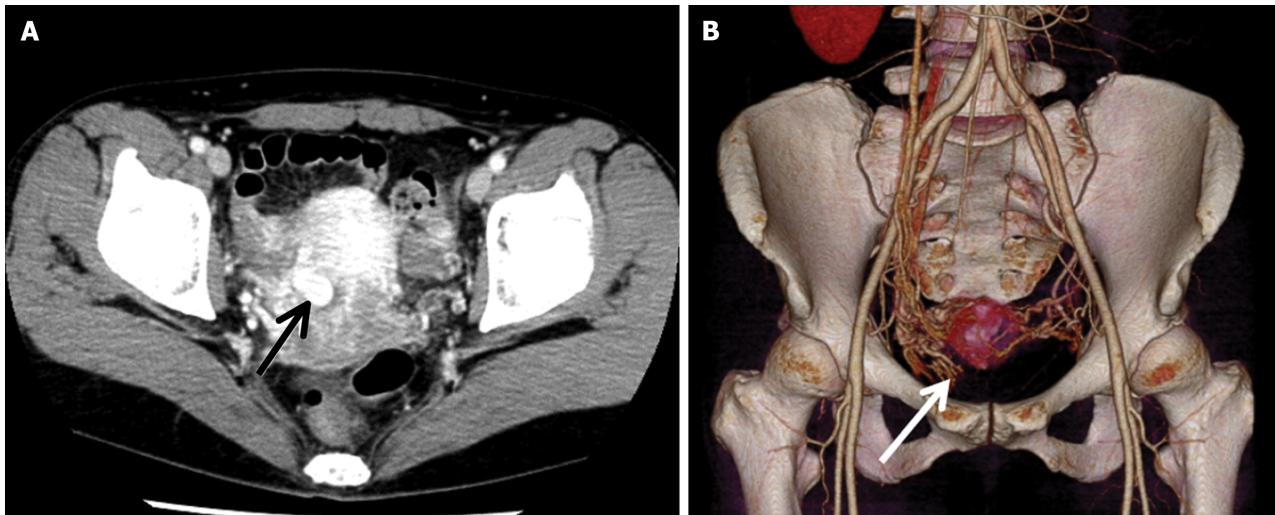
Pelvic contrast-enhanced computed tomography. A: A contrast-enhanced mass (arrow) is evident in the arterial phase; a uterine artery pseudoaneurysm was diagnosed (dynamic imaging); B: Three-dimensional image reconstruction shows the uterine artery and the uterine artery pseudoaneurysm (arrow) continuous with it.
